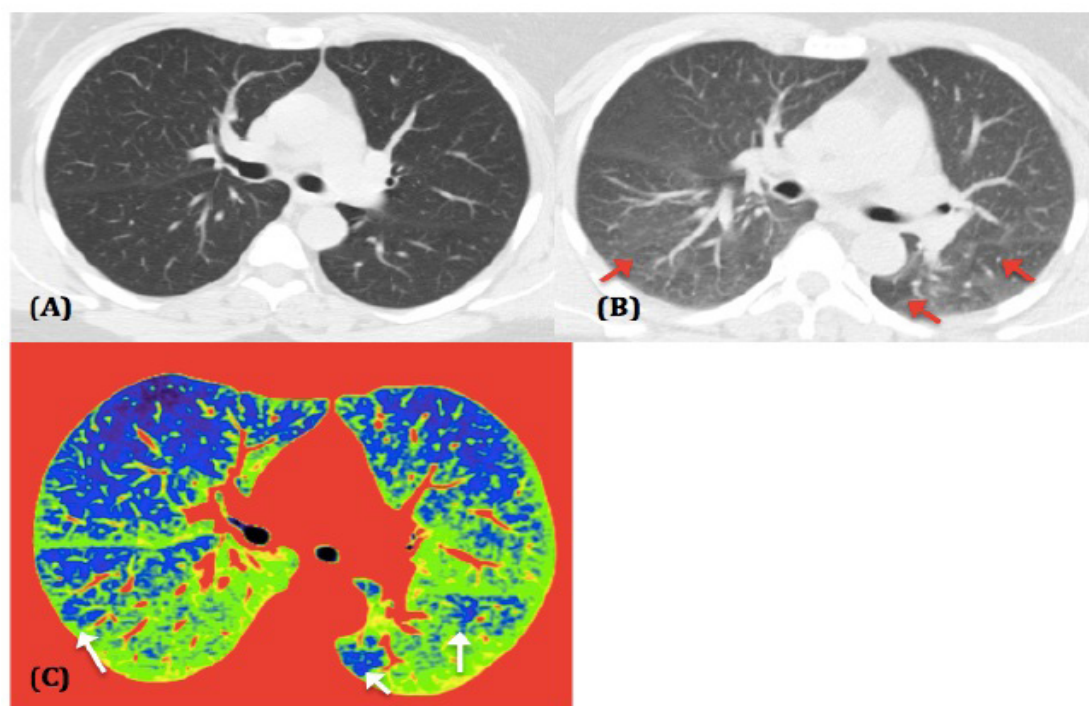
A 45-year-old female asthmatic patient with recurrent attacks of cough and wheezes. (A) Axial inspiratory CT image is normal. (B) Corresponding expiratory CT image shows lobular areas of air trapping (red arrows). (C) Corresponding inspiratory CT image displayed in color-coded narrow window shows clearly posterior lobular areas of air trapping in blue (white arrows).
